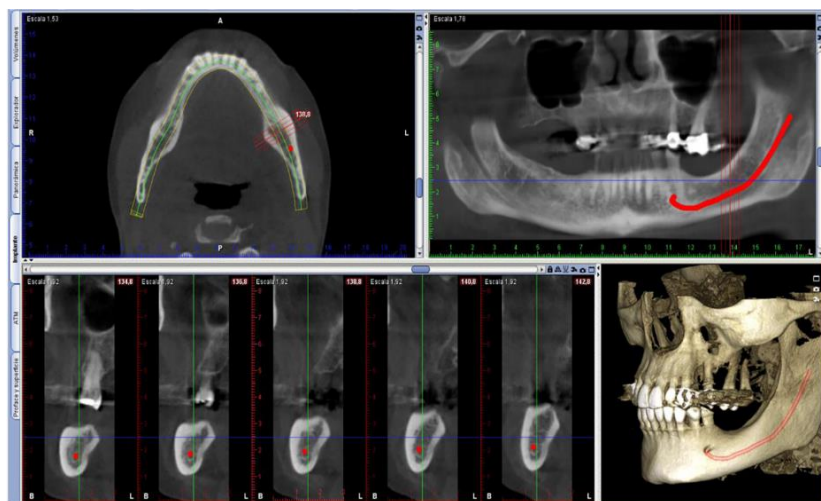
CBCT reconstructions of a mandible to identify the three-dimensional course of the mandibular canal. The mandibular canal is highlighted in cross-sectional and panoramic views (Planmeca Romexis Software®).
